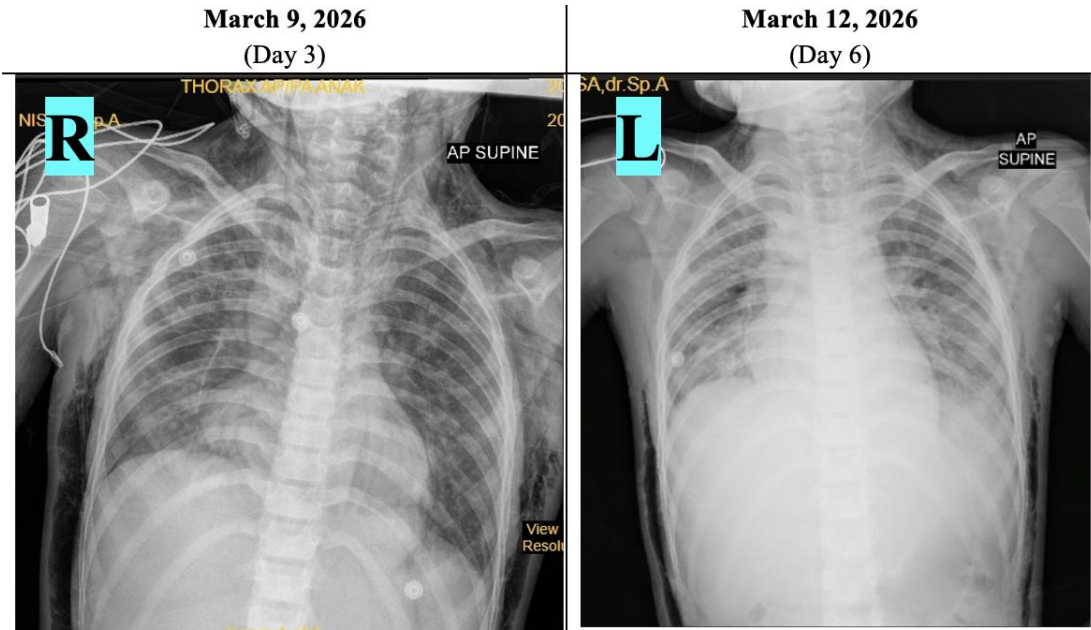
Serial chest radiographs with pneumomediastinum (R) to resolution (L)
